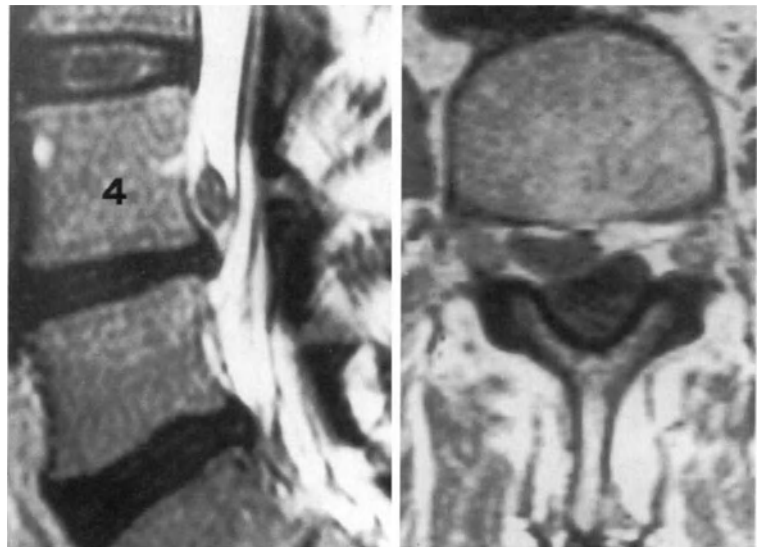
Turbo spin-echo T2-weighted sagittal, and spin-echo T1-weighted axial, images showing a migrated disc herniation originating from the L4-L5 disc. The disc fragment has migrated cranially on the right.
